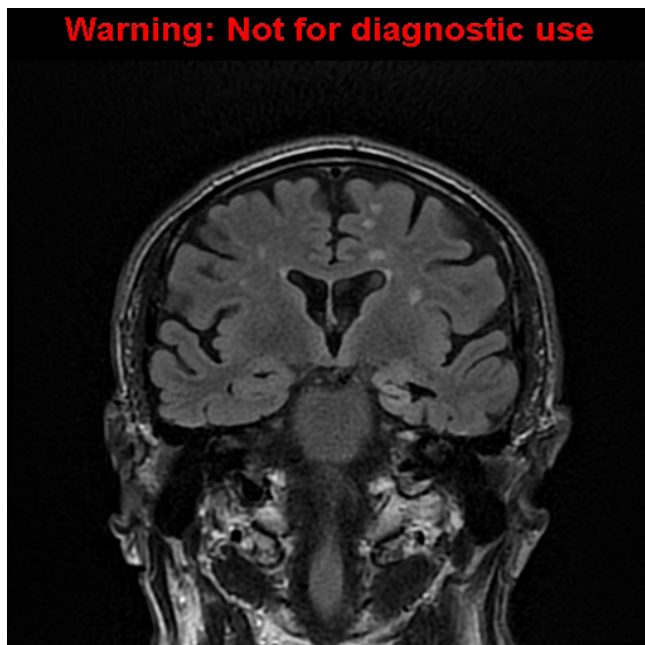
Coronal FLAIR MR Image of the brain showing the high signal intensity involving the hippocampus. Vascular related white matter diseases, which are chronic microangiopathic.
